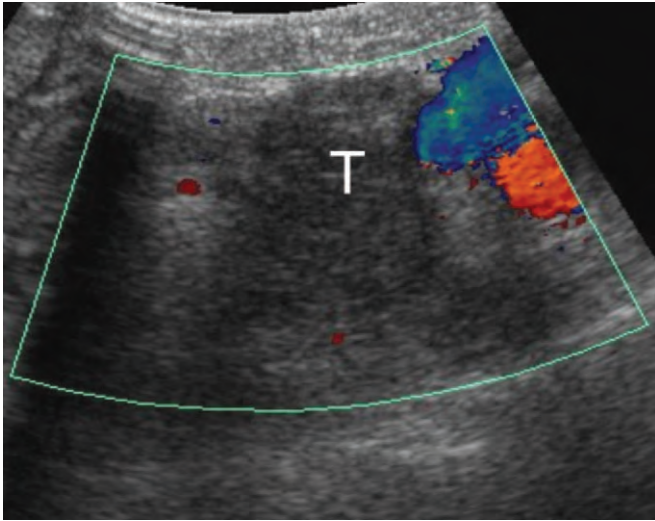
Intraoperative ultrasound (IOUS) that demonstrates a small, hypodense sonolucent tumor (T) within the head of the pancreas to the right of the superior mesenteric vein (blue) and artery (red). This tumor was an insulinoma and IOUS facilitated the enucleation.
